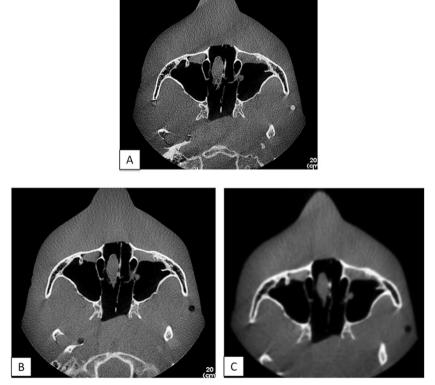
Axial sections of different CBCT protocols scanned at levels of the maxillary sinus reveal the variations in image quality: (A) Protocol 1, (B) Protocol 2 and (C) Protocol 3.
